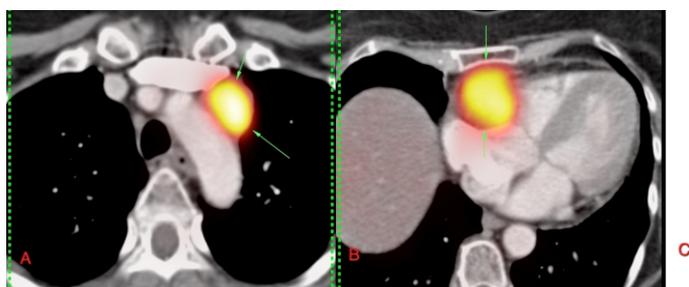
(A-C): PET/CT. The axial fused PET/CT image (A) through the upper chest shows a markedly active left para-aortic node (arrows), with similar activity in the right cardiac mass (arrows in B). The PET image (C) shows both these well (arrows).
